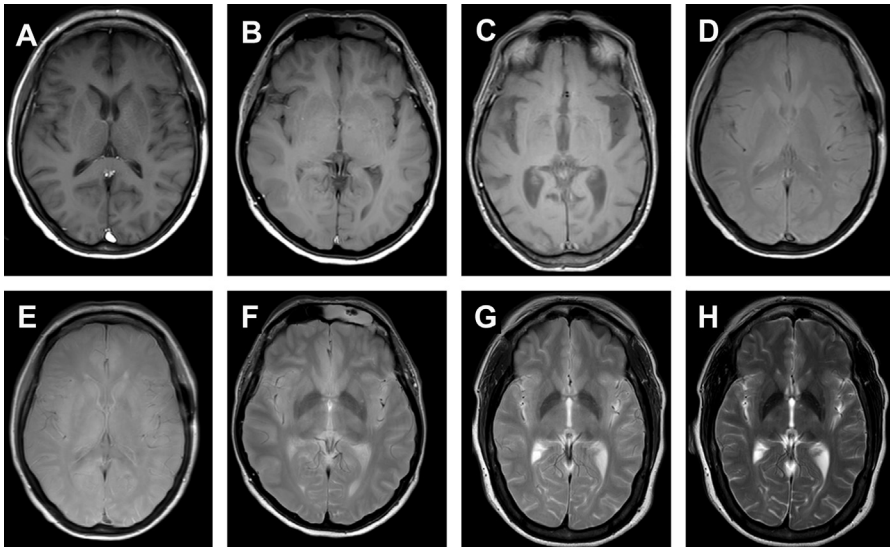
Effect of sequence parameters on image contrast. In (A) through (D), TE is fixed at 10 ms while TR is set at 400 ms, 1000 ms, 1800 ms, and 3000 ms, respectively. This shows white matter signal decreasing and gray matter and CSF signal increasing as image appearance shifts from typical T1-weighted contrast (A) to typical proton density contrast (D). In images (E) to (H), TR is fixed at 3000 ms while TE is set at 10 ms, 70 ms, 90 ms, and 150 ms. The signal of white matter and deep gray matter structures decreases while the signal of CSF remarkably increases as image appearance shifts from a proton density contrast (E) to typical T2-weighted contrast (H).
